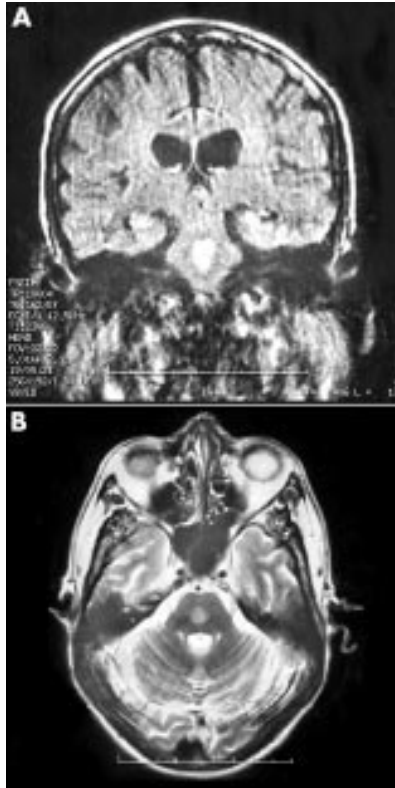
Coronal FLAIR magnetic resonance image (MRI) (A) and axial T2 weighted MRI (B) from case 2, showing high signal within the pons consistent with central pontine myelinolysis.
